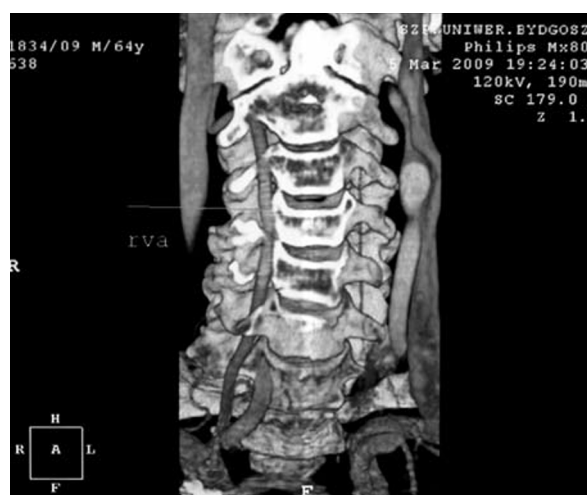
Computed tomography angiogram of the carotid and vertebral arteries within the section preceding the skull reveals a hypoplastic left vertebral artery, 1.9 mm in diameter
